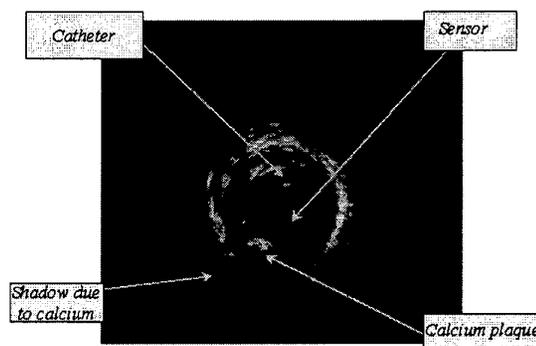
Slice of artery obtained by intravascular ultrasound
